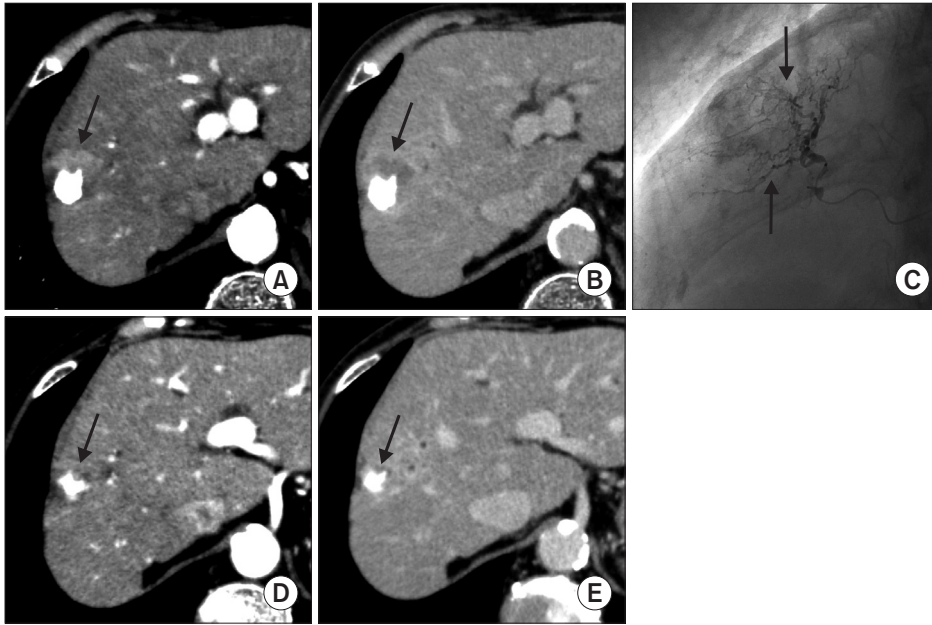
Repeated alternate infusion of cisplatin and sparse gelatin slurry under balloon-occlusion (RAIB-TACE) for a recurrent nodule after conventional super-selective lipiodol (c-TACE). Dynamic computed tomography (CT) showed a recurrent nodule (arrow; A, B) 1 month after c-TACE performed at a neighboring hospital. Selective digital angiography showed tortuous corkscrew tumor feeders (arrows; C), and RAIB-TACE was performed via anterior superior subsegment artery. Dynamic CT 1 year after RAIB-TACE showed complete remission of the nodule (black arrow; D, E).
